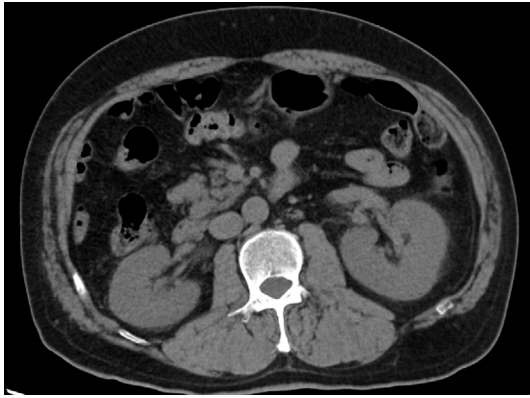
Normal abdominal CT findings. Abdominal CT showed no bilateral hydronephrosis or abnormal renal morphology.
